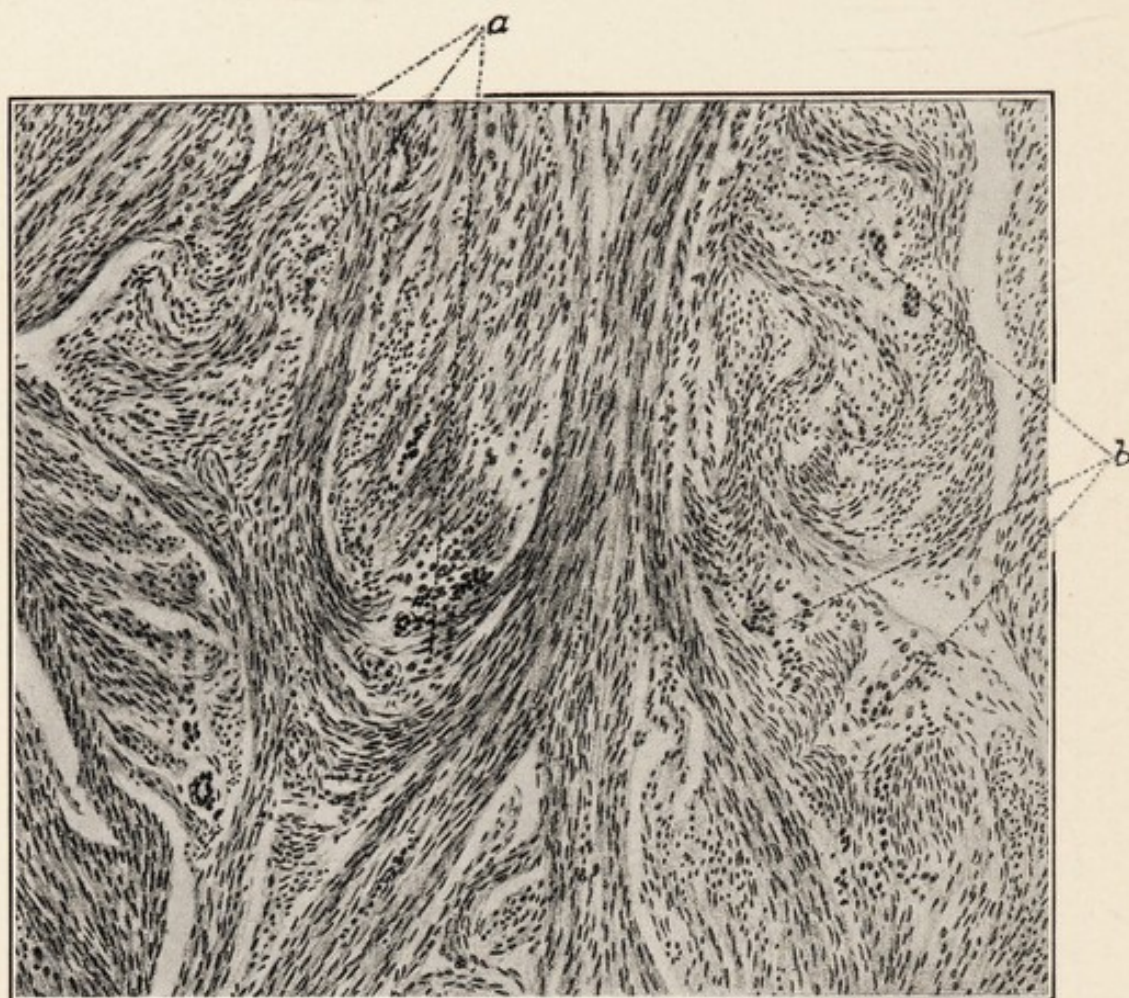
THE UTERUS WAS REMOVED TEN DAYS AFTER A COMBINED RADIUM AND X-RAY APPLICATION OF ABOUT 130 PER CENT E. S. D. Note the marked fibroblastic infiltration and almost complete disappearance of the carcinoma cells.
